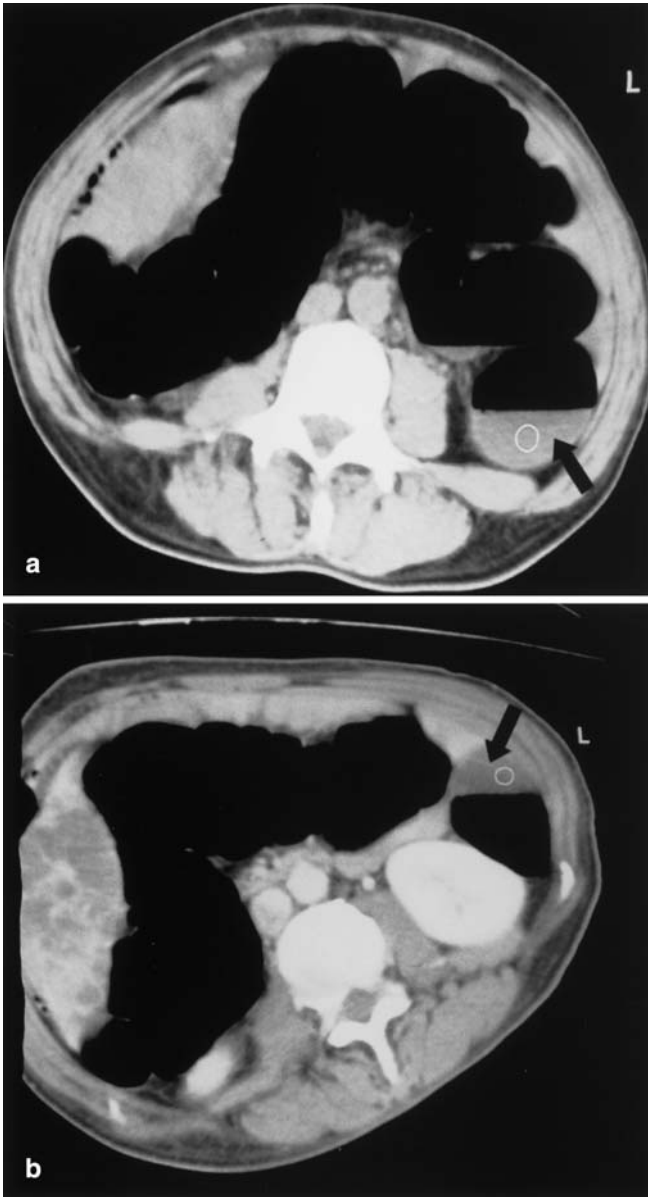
Adenocarcinoma in the descending colon (*arrows*) on non-contrast, a supine and b contrast-enhanced, prone axial CT image. The ROI circle is on the lesion to measure its CT attenuation which was 51 HU on non-contrast images and 90 HU on post-contrast images
